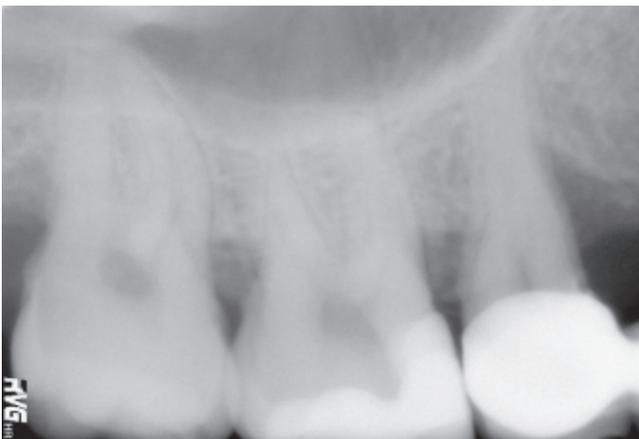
Radiograph after treatment.
